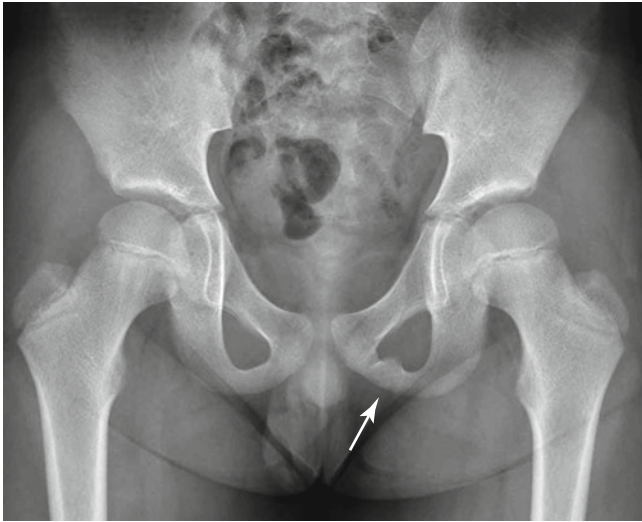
Asymmetric ischiopubic synchondrosis in an 8 year-old boy.* Anteroposterior pelvis radiograph shows asymmetrical bulging lesion (*arrow*), mimicking healing fracture with callus formation at the left ischiopubic junction
